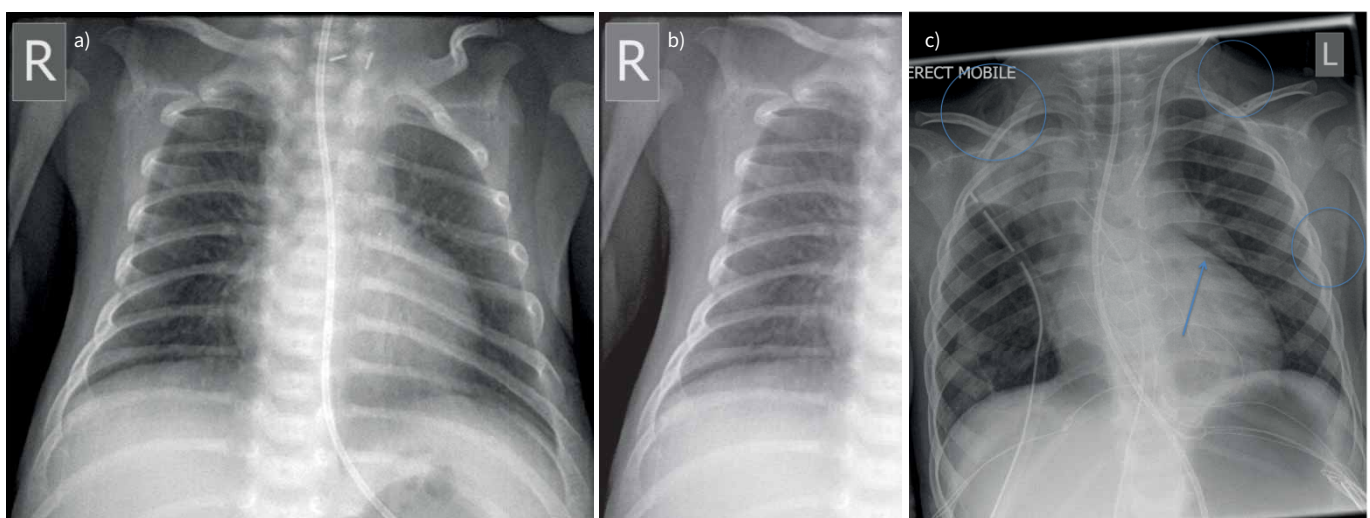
a) Initial chest radiograph of patient A; b) focused in review of figure 7a (patient A); c) patient B for comparison.
